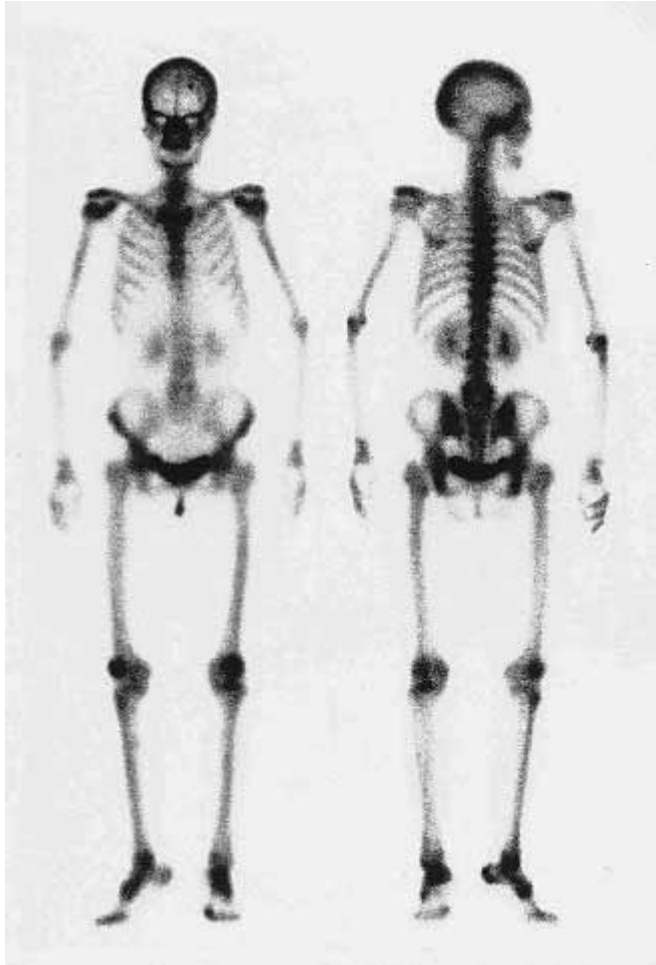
A demonstration of a "normal" bone scintigraphy. This is an 82 year-old woman with lung cancer. Bone scintigraphy clearly demonstrates her whole body skeleton. No soft tissue shadow is present except in the kidneys and bladder.
